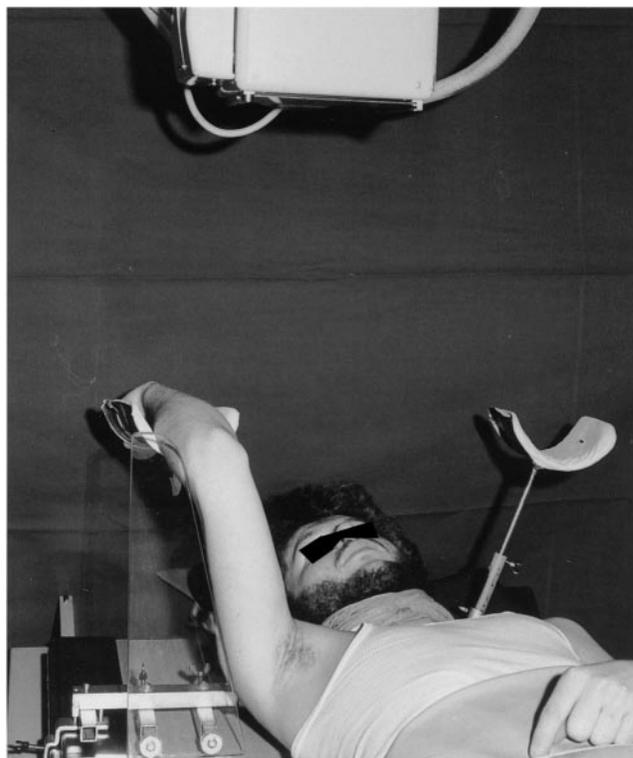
Special holding device for radiograph in plane II.
